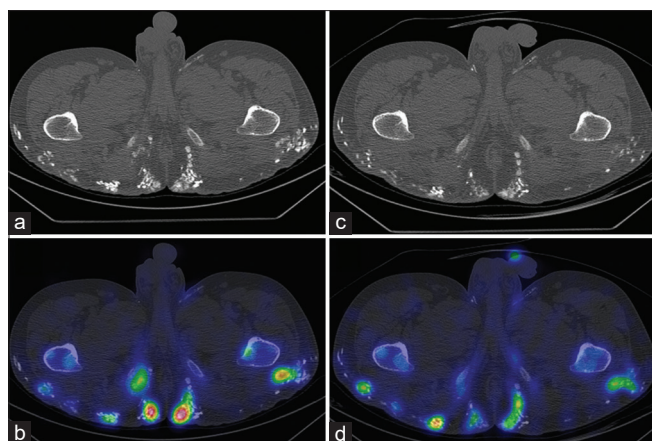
(a and b) Baseline single-photon emission tomography-computed tomography images shows tracer uptake in the multifocal calcifications in the subcutaneous fat of the gluteal region. (c and d) Follow-up single-photon emission tomography-computed tomography images show regression in the intensity of tracer uptake and minimal regression in the extent of calcification suggestive of partial response to treatment
